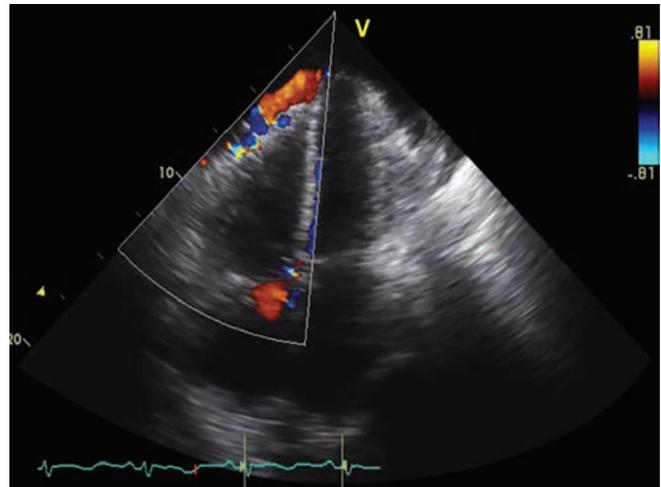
2D echocardiogram—Apical four-chamber view demonstrating abnormal color flow Doppler signals around the right ventricular free wall and apex.
